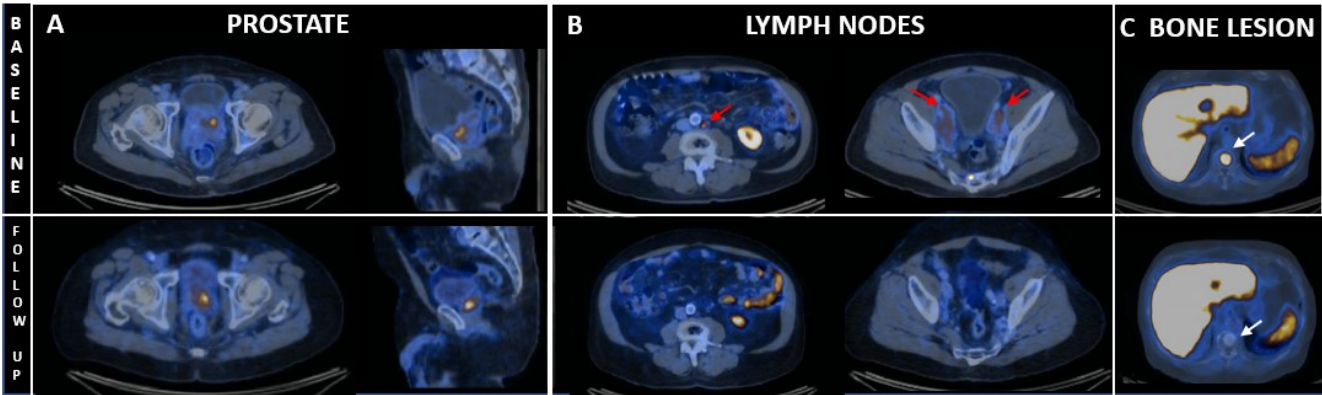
Serial fused F-18 PSMA PET/CT images captured from baseline to follow up.
